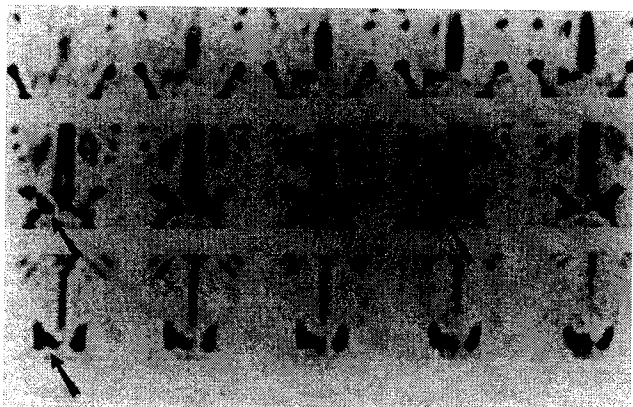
Coronal SPECT bone scan of the pelvis in case 7, performed 2 weeks after the onset of symptoms, demonstrates intense tracer uptake in the right sacroiliac joint and sacral ala (arrows).
